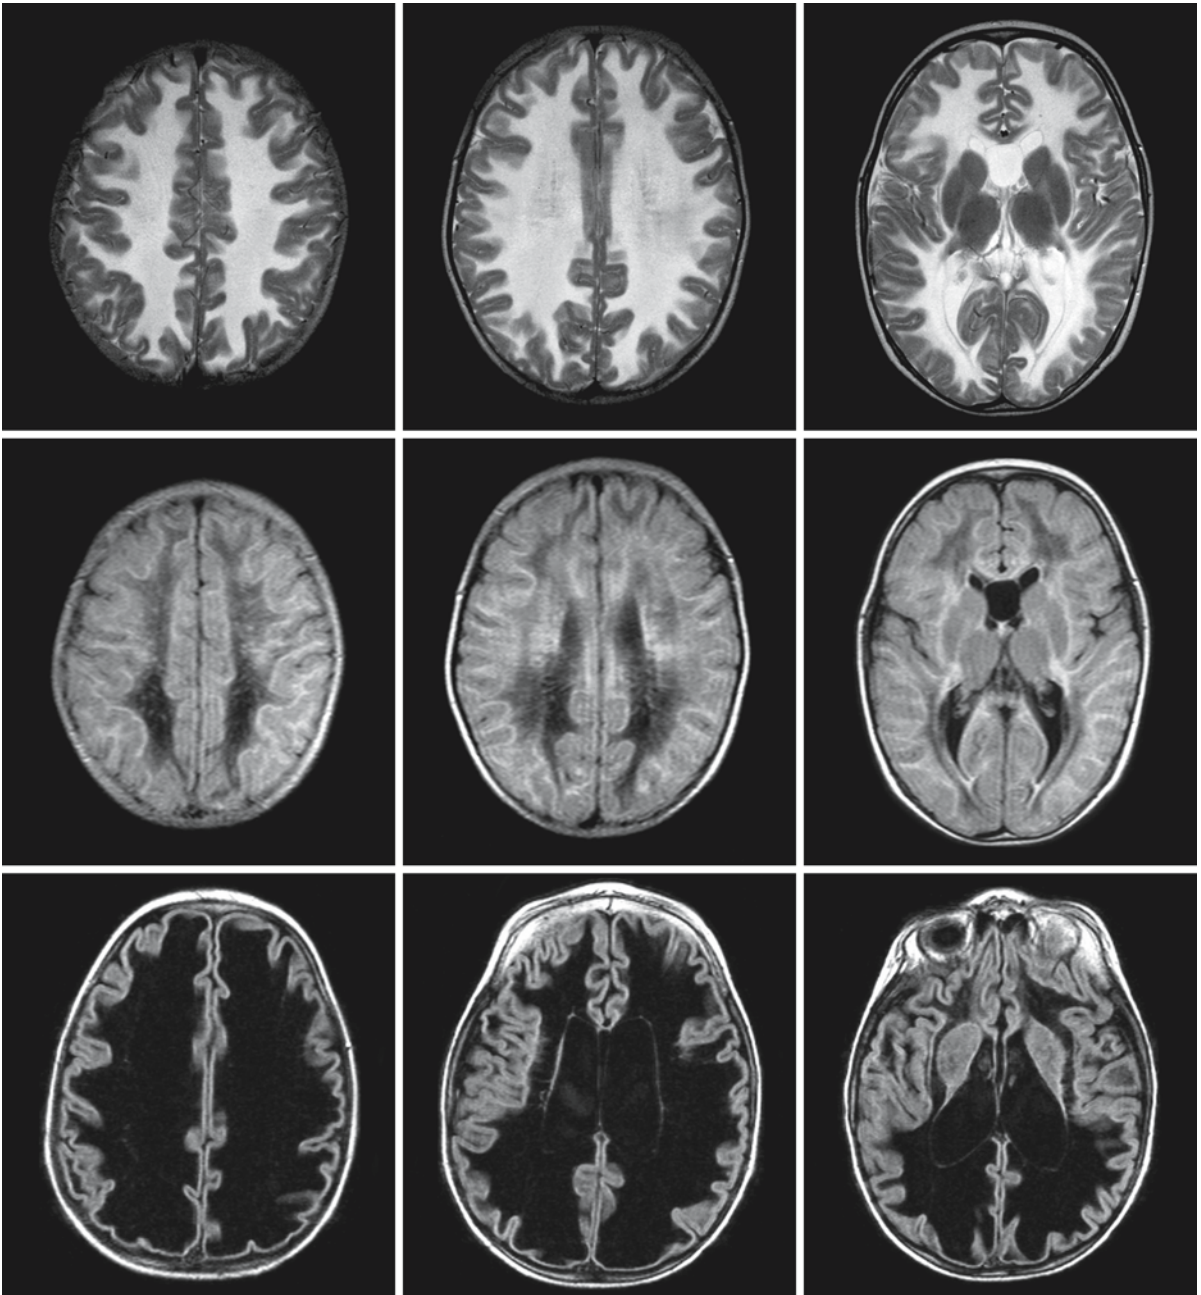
The T₂-weighted (*first row*) and FLAIR images (*second row*) of a severely affected 2-year-old boy with VWM show the characteristic abnormalities. Note the large cavum septi pellucidi. Ten months later he has lost almost all functions. He is blind and has no intentional movements. The MRI was performed because he had papilledema at funduscopy. The FLAIR
